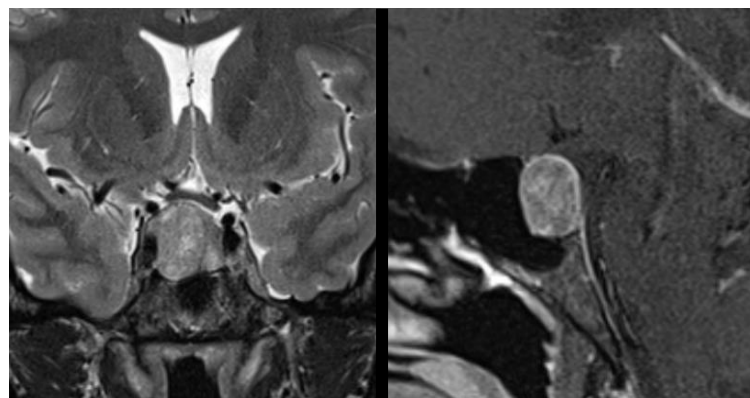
MRI finding of pituitary adenoma - measuring 14 x 19 x 17 mm.
